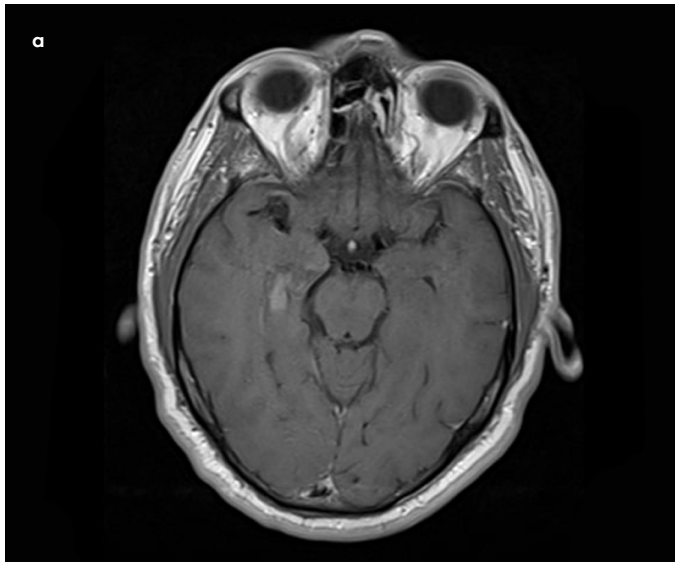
a, b. T1-weighted axial MRI showing hyperintense lesion with contrast enhancement in the right temporal region at disease onset. MRI: magnetic resonance imaging.
